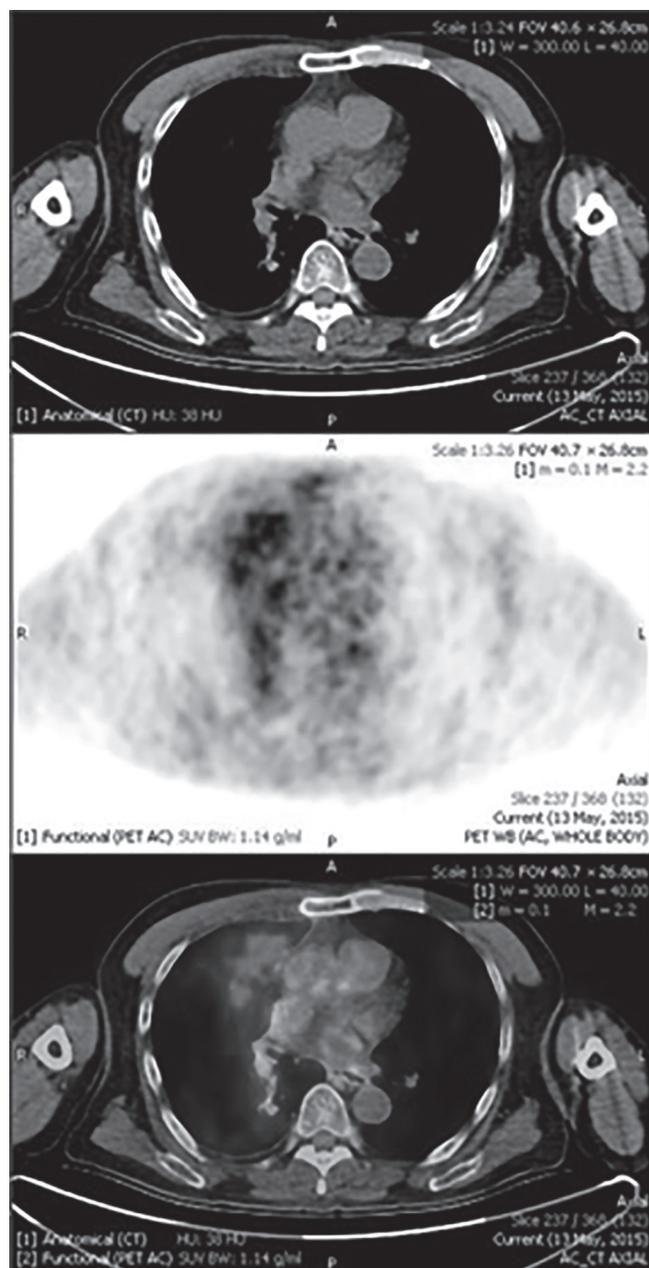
PET-CT images during follow-up (May 2015). Predominantly metabolically inactive lesion in right lung lower lobe superior segment with mild right basal pleural thickening.
